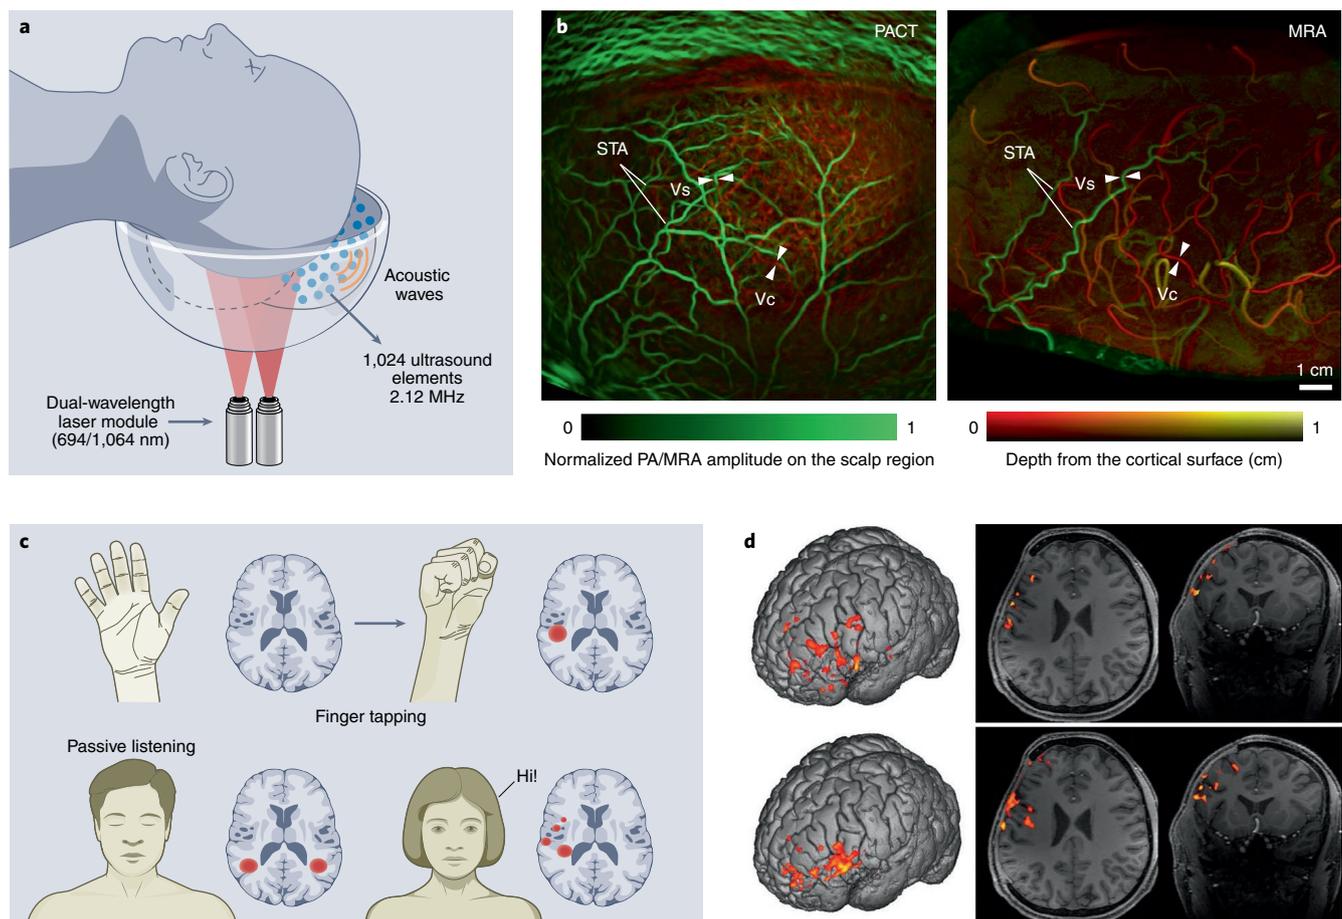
Functional photoacoustic computed tomography (fPACT) of the adult brain. a, fPACT with dual-wavelength illumination and 1,024 ultrasound transducer elements with a central frequency of 2.12 MHz. b, fPACT angiography and magnetic resonance angiography (MRA) of the same brain section. STA, superficial temporal artery; Vs, scalp vessel; Vc, cortical vessel. c, Different cognitive tasks (speaking, finger tapping, lip puckering, tongue tapping and passive listening) activate different areas of the brain. d, Haemodynamic responses (overlaid on a three-dimensional representation of the brain (left) and on actual MRI brain scans (right)) measured by fPACT and fMRI for the same brain while speaking one word. Panels b and d reproduced with permission from ref. ², Springer Nature Ltd.
